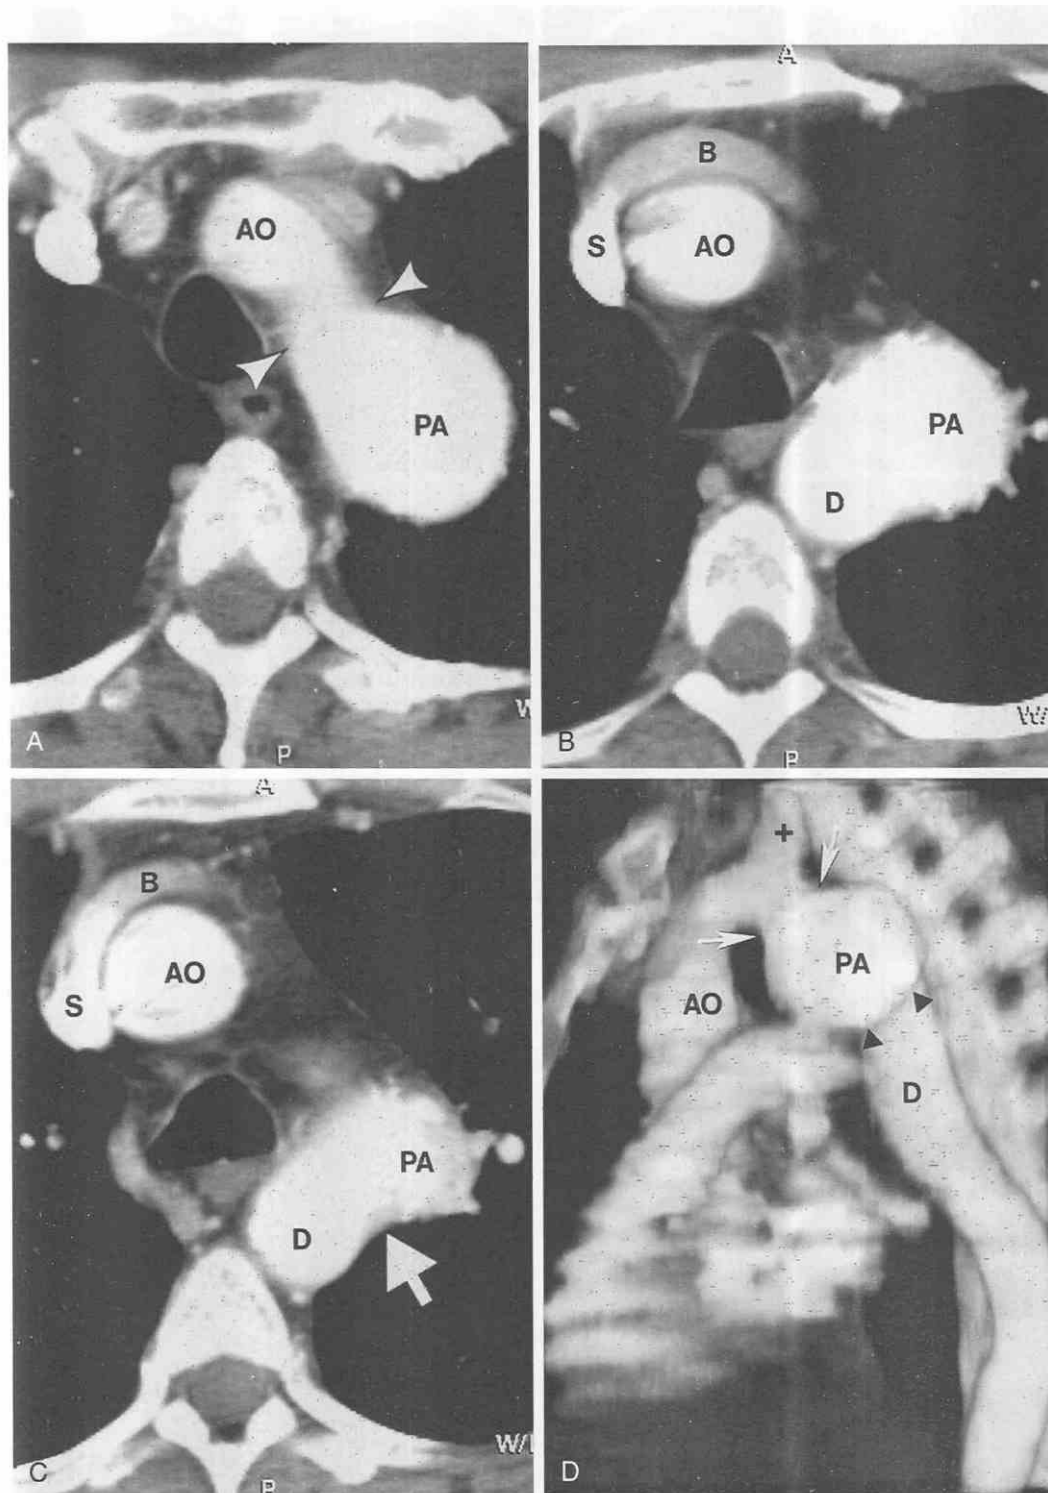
Pseudoaneurysm after repair of aortic coarctation. A–C, Contrast-enhanced CT shows pseudoaneurysm (P) at site of coarctation repair. A narrow isthmus (*arrowheads* in A) can be seen between the pseudoaneurysm and the transverse aorta, and a wide connection (*arrow* in C) can be seen between the pseudoaneurysm and the descending aorta. D, Oblique volume-rendered maximal intensity projection image clearly shows relationship of pseudoaneurysm to proximal (*arrows*) and distal (*arrowheads*) aorta as well as the brachiocephalic artery (+). Three-dimensional reconstructions of CT angiograms display anatomy in a more familiar perspective to clinicians than axial CT images. A, ascending aorta; B, brachiocephalic vein; D, descending aorta; S, superior vena cava.
